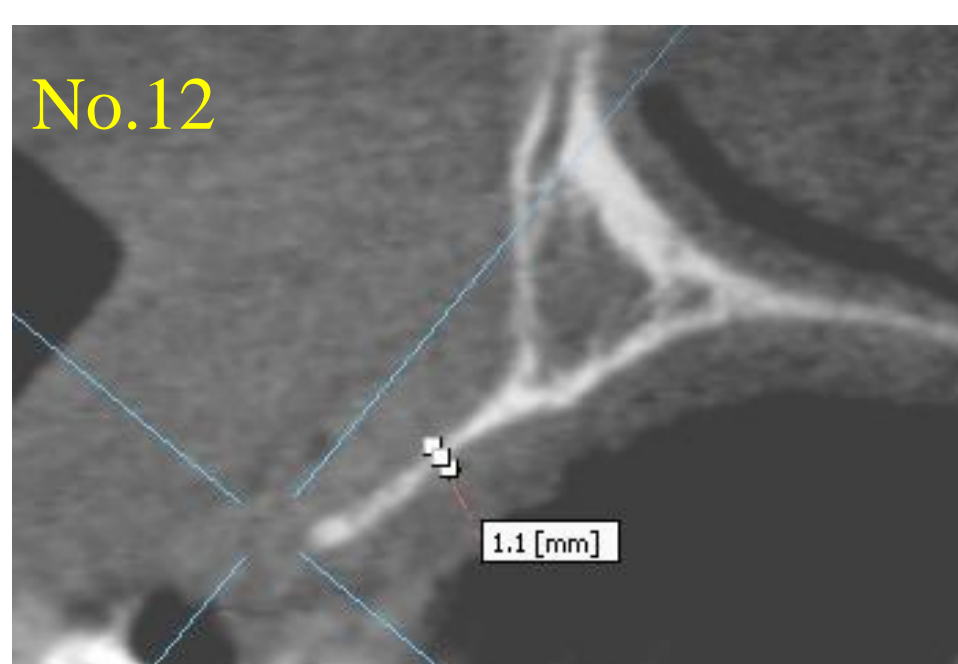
Pre operative CT scan(cross-sectional slice) Alveolar bone at No.12 was 1.1mm in width and at No.22 was 1.4mm. Both sides showed the width was insufficient although the height was enough.
